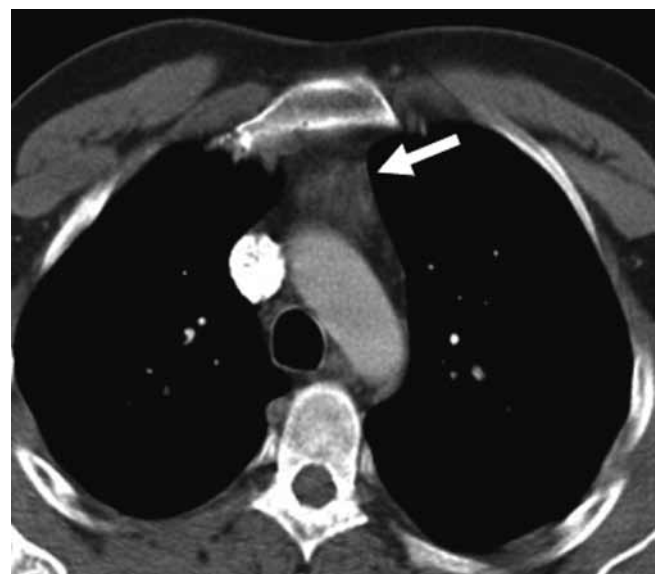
Thymic hyperplasia in a 26 year old boy who completed chemotherapy for testis carcinoma. CT shows enlargement of the thymus in the prevascular space (arrow).
